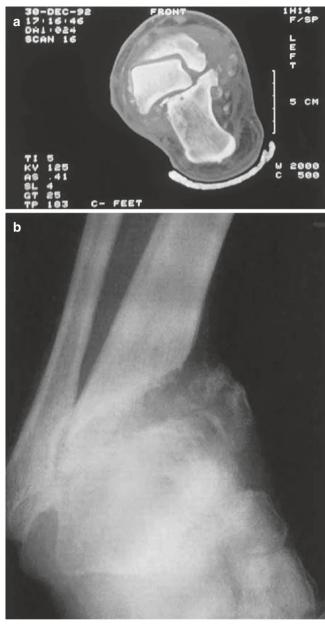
Pattern IV (a) Subtalar joint dislocation diagnosed on CT Scan. (b) Acute ankle Charcot with medial malleolar fracture and medial displacement of foot
